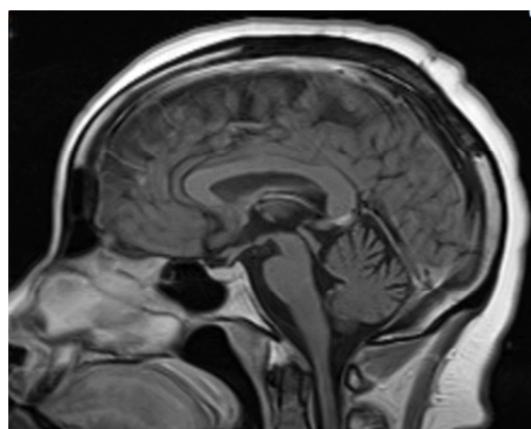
Brain MRI showing cerebellar atrophy.
